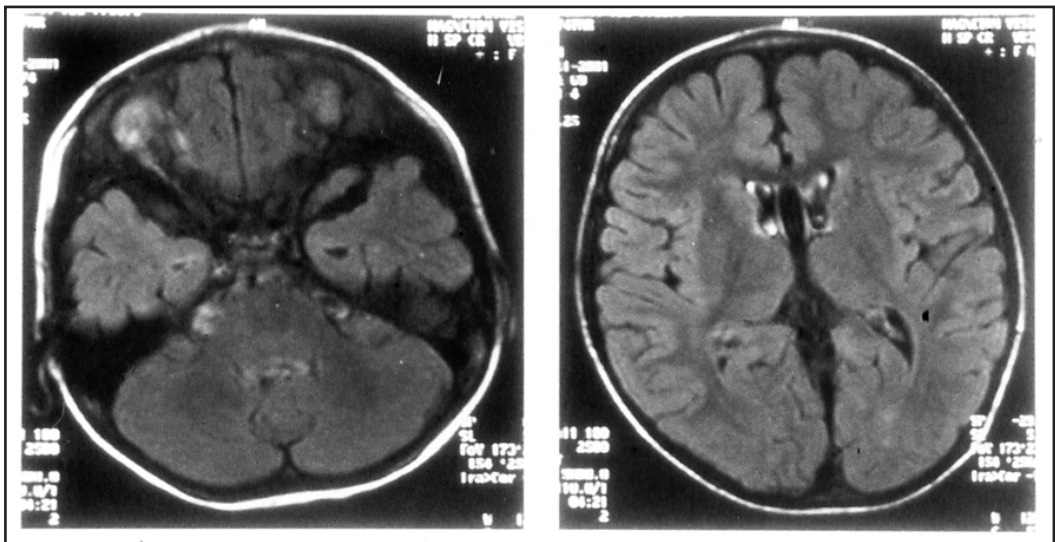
MRI brain at six-month follow-up. (A) T2-FLAIR image shows a normal pons. (B) The caudate nuclei and thalami are also normal
